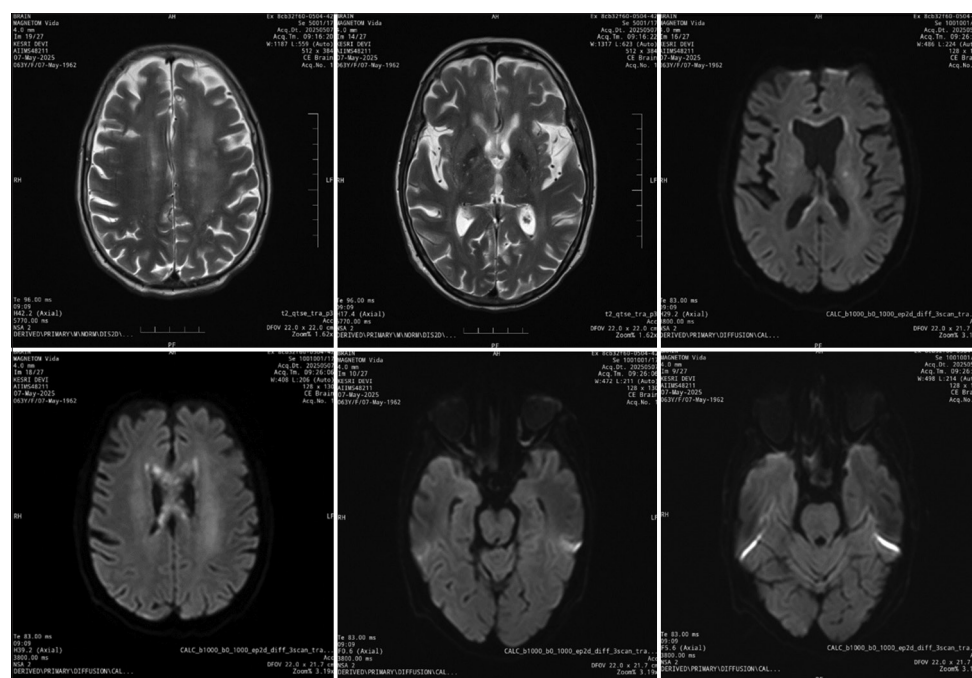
Contrast-enhanced magnetic resonance imaging brain
